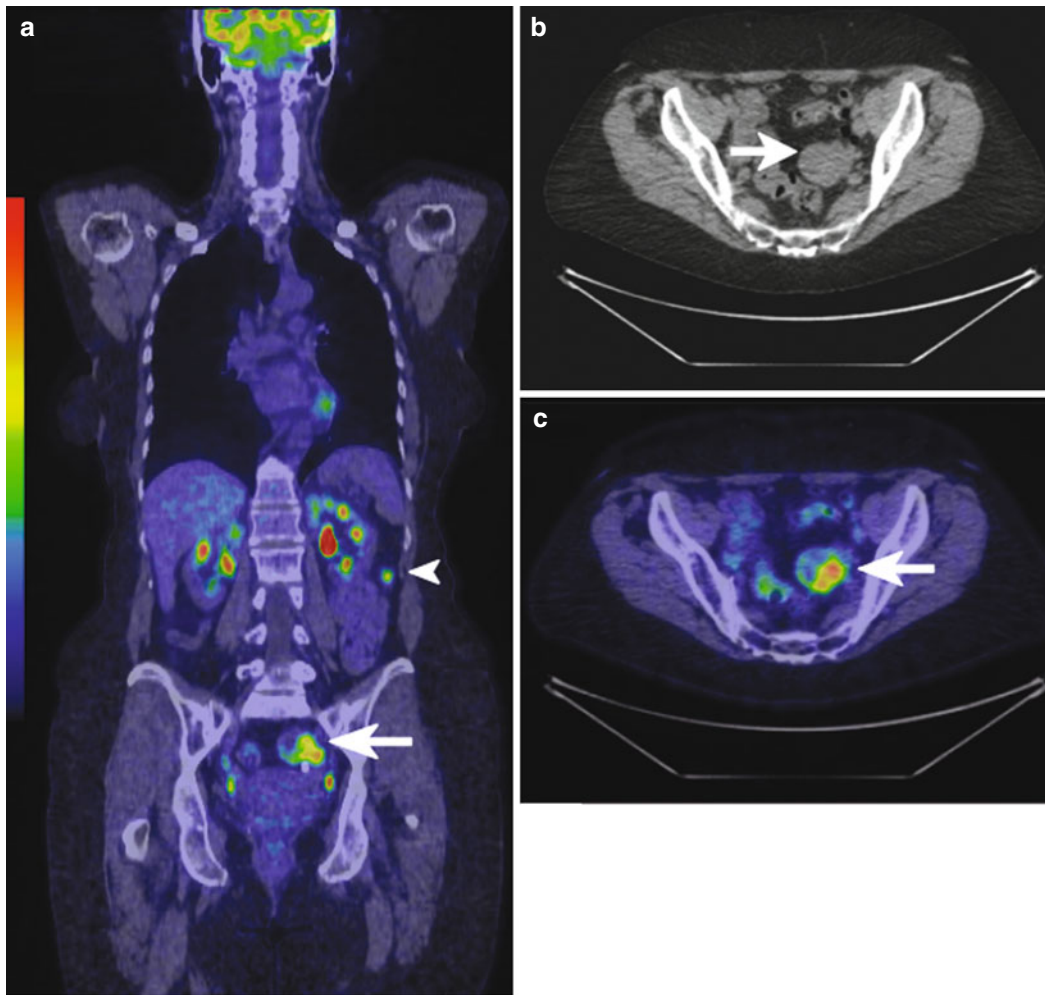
A 58-year-old woman previously underwent a laparoscopic subtotal colectomy for a moderately differentiated T4N1 adenocarcinoma of the proximal descending colon followed by adjuvant FOLFOX (fluorouracil, folinic acid, oxaliplatin) chemotherapy. On routine clinical follow-up 18 months after surgery, a raised serum CEA level of $19 \mu\text{g/l}$ was detected (normal range: $0\text{--}5.0$) which rose to $51 \mu\text{g/l}$ within 2 months. Diagnostic CT scan of the chest, abdomen and pelvis did not demonstrate any significant abnormalities to suggest metastatic disease. FDG PET-CT for further evaluation was then undertaken. (a) Coronal-fused PET-CT, (b)
